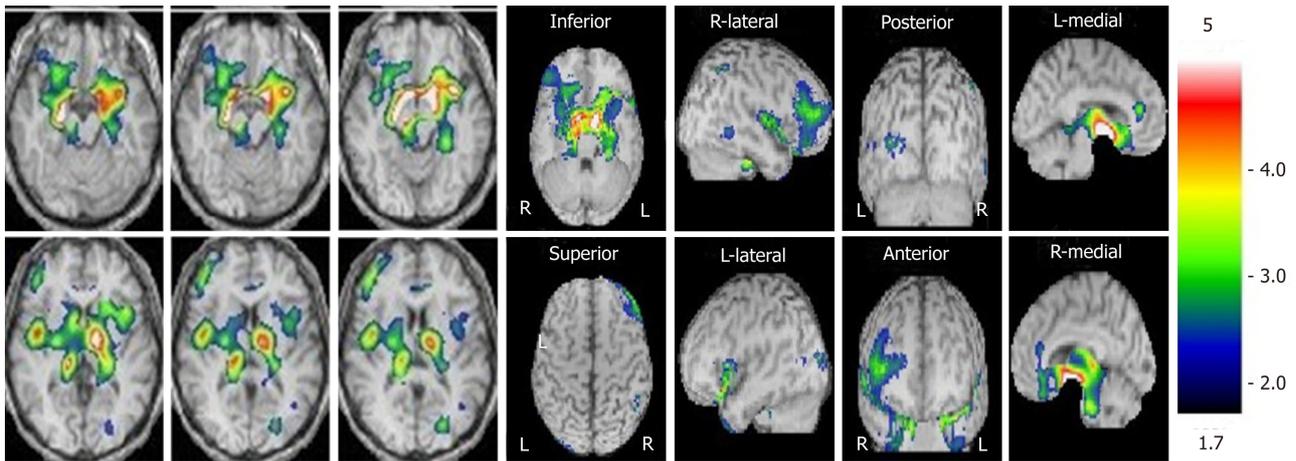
Brain perfusion single photon emission computed tomography (easy Z-score imaging system) of the proband (65 yr).
